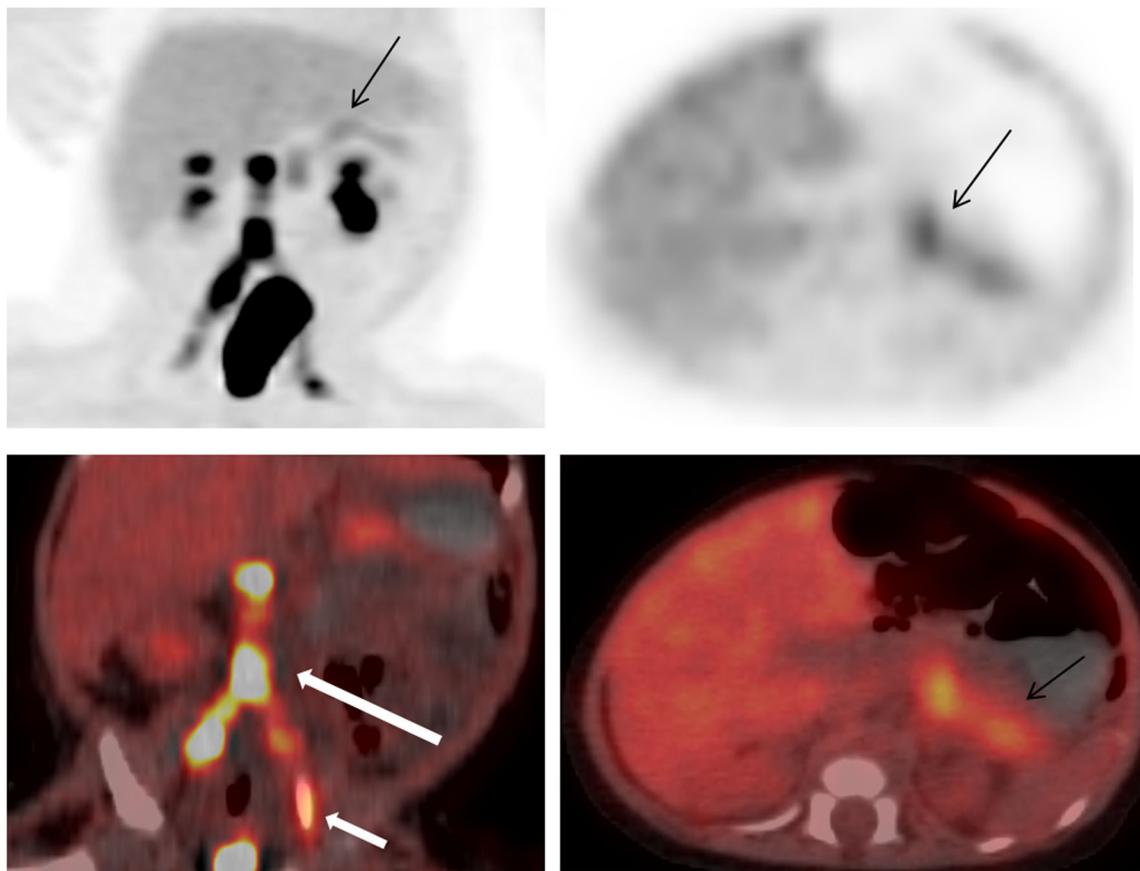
MIP image, axial and coronal sections of ^{18}F -DOPA PET/CT. Scan shows diffuse uptake in the pancreas with no focal lesion (black arrow), physiologic excretion of radiotracer into genitor-urinary system
